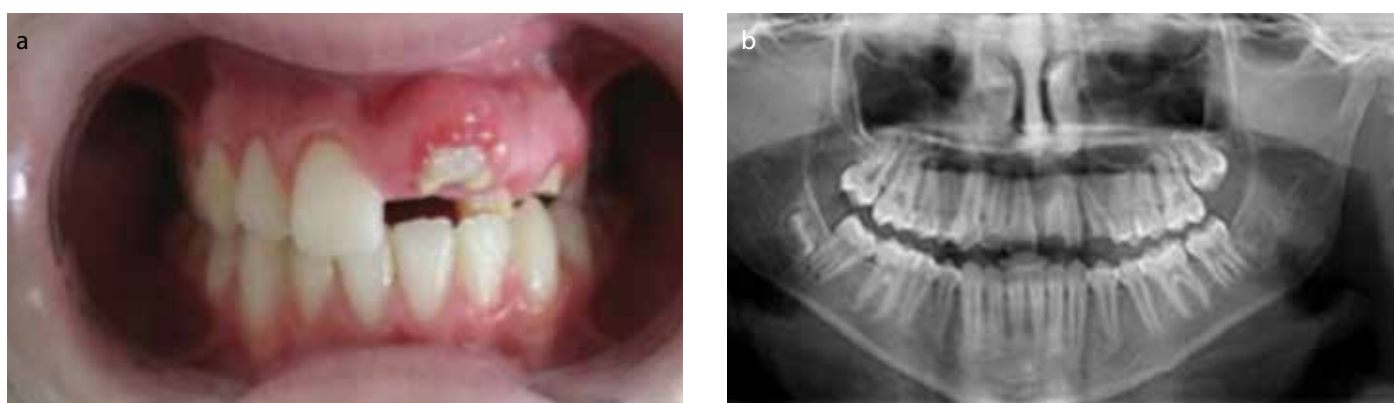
a, b. (a) Intraoral (b) radiographic view after periodontal surgery.
